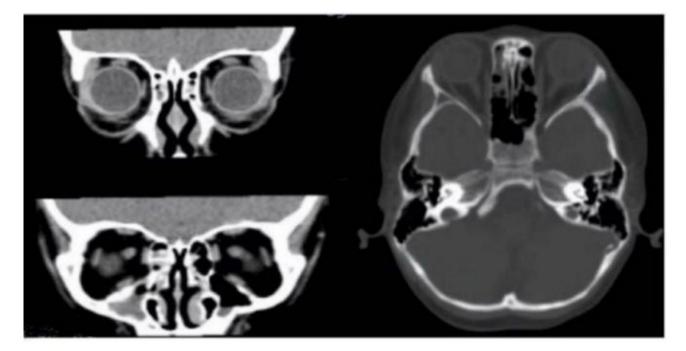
Orbital CT images of the child with APS-2
